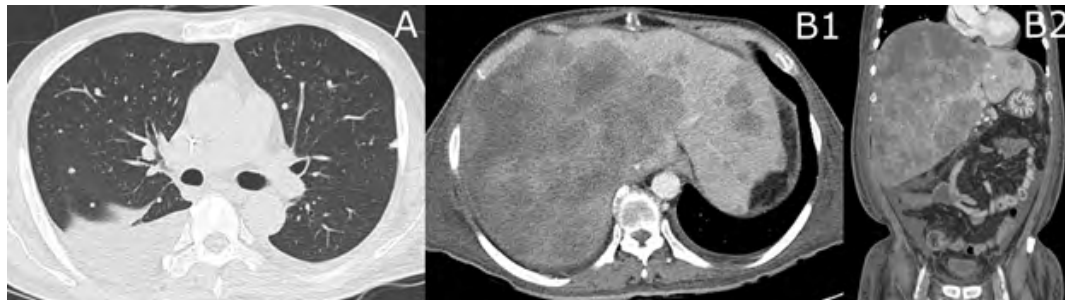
(A) Chest computed tomography (CT) scan discovered markedly increased size and number of metastatic nodules in both lungs with pleural effusion. (B1) Coronal and (B2) sagittal abdominal CT showed increased number and size of extensive hepatic metastasis with ascites.
